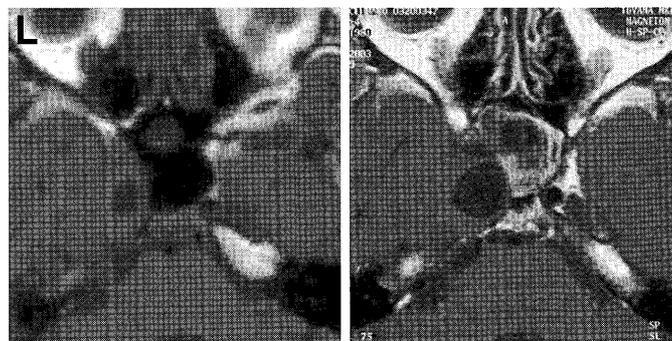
T₁-weighted magnetic resonance images with contrast medium showing an encephalocele in the right middle fossa (left) and enlargement of the encephalocele (right).
